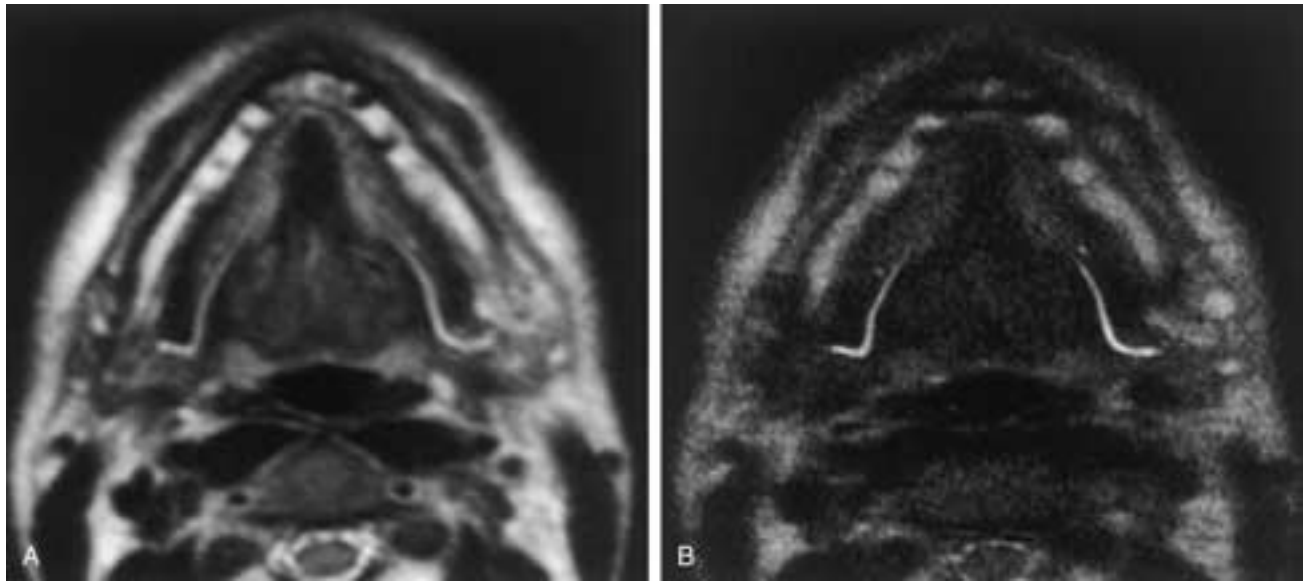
MR sialography of the submandibular gland ducts. A, Axial MR image with TR = 4.3, TE = 100, 1 NEX. B, Axial MR image with TR = 10.9, TE = 87, and 1 NEX.
